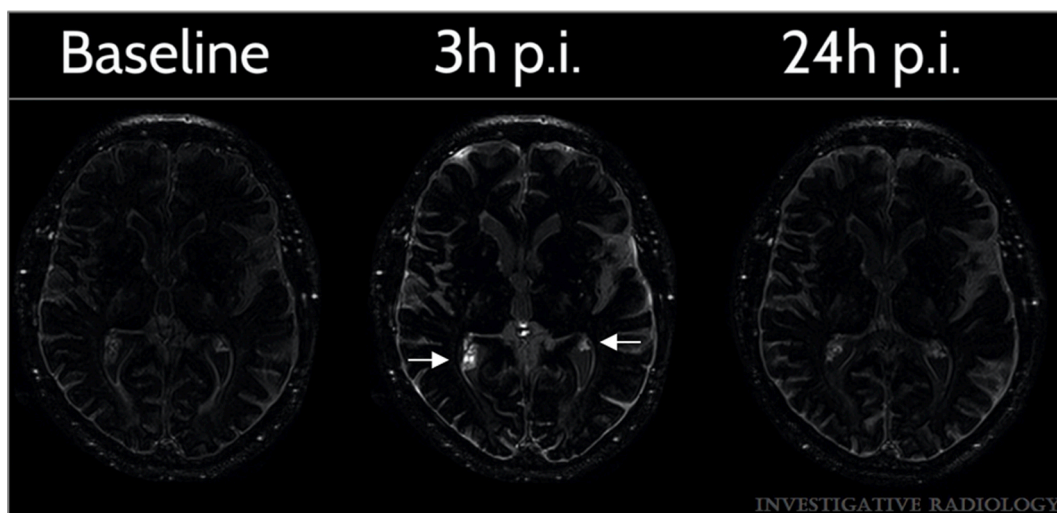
Gadolinium enhancement in the choroid plexus using heavily T2-weighted fluid-attenuated inversion recovery. Images obtained from a 64-year-old male patient with bronchial carcinoma, without neurological disorder and with normal renal function. Gadolinium enhancement after intravenous administration of a single dose of gadolinium-based contrast agent is detected with heavily T2-weighted fluid-attenuated inversion recovery, with first pre-contrast baseline, then 3 h post injection (3 h p.i.) and lastly 24 h post injection (24 h p.i.). The choroid plexus demonstrates strong contrast enhancement after 3 h (arrows) compared to baseline. Figure adapted from Deike-Hofman et al. (2019) (118) with permission.
